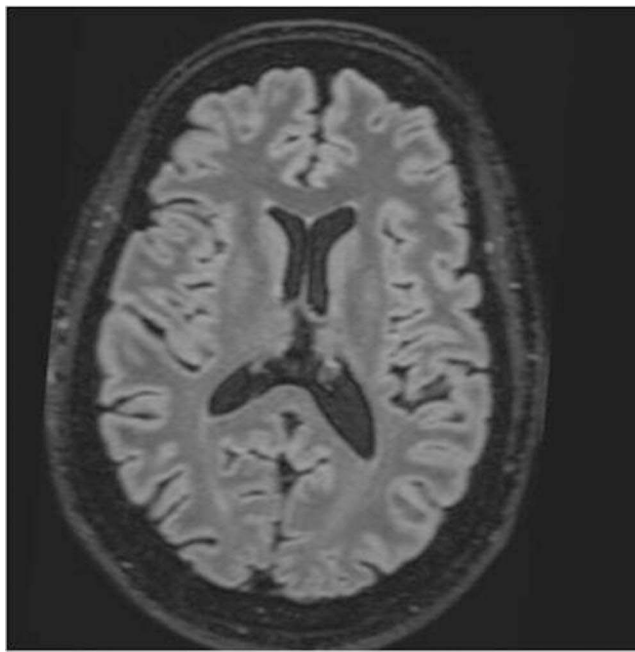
Brain MRI showed mild lateral asymmetry of the lateral ventricles in favor of the left side.
